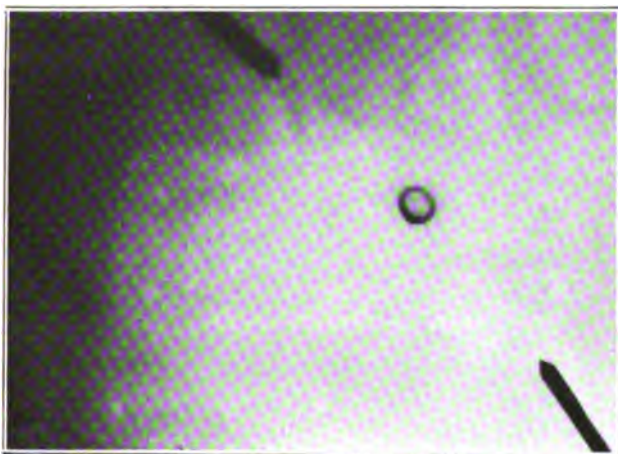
Roentgenogram showing sponge through a 200-pound patient.
